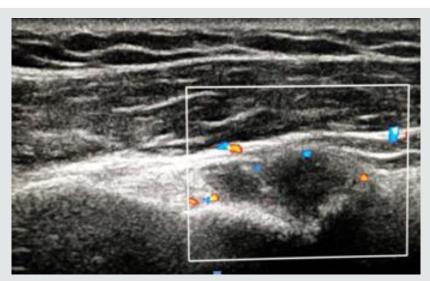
Echo-doppler - rotator's interval with characteristic hyperemia of synovial inflammation.
